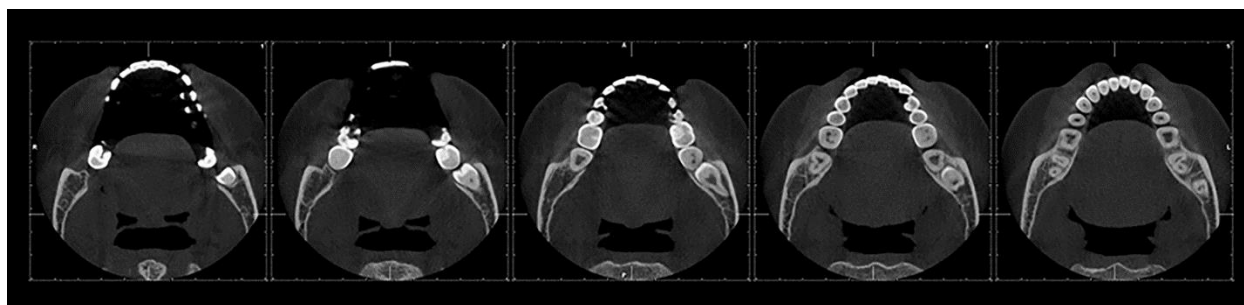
Superior, central and inferior sections on CBCT
